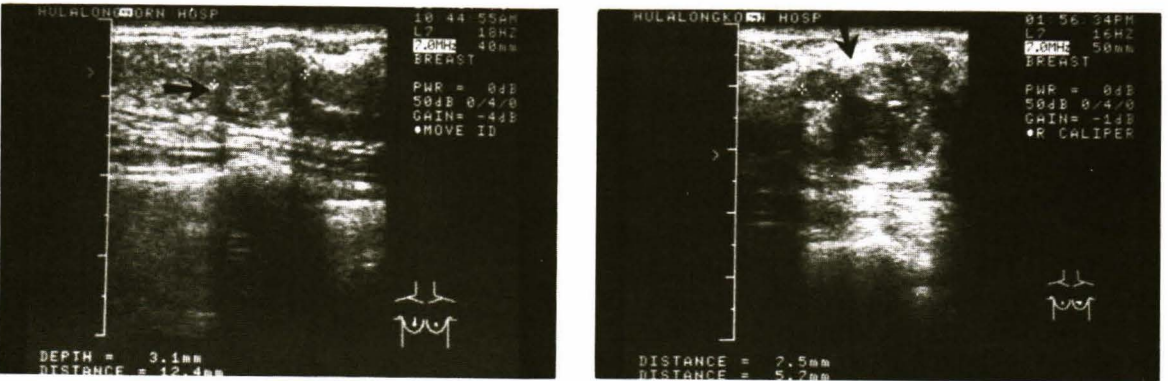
Ultrasonography showing a well defined oval shaped, inhomogenous low echoic mass at right subareolar area (arrow).
